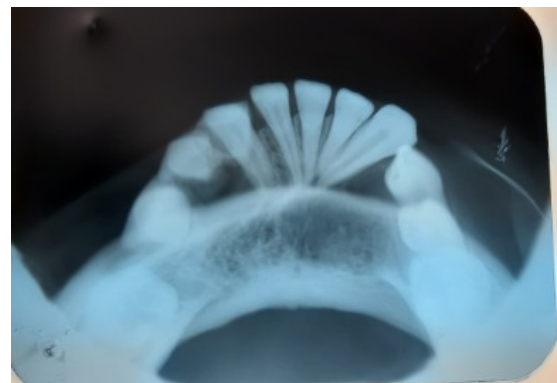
Occlusal radiograph showing well defined radiolucency and pathological migration of teeth.
